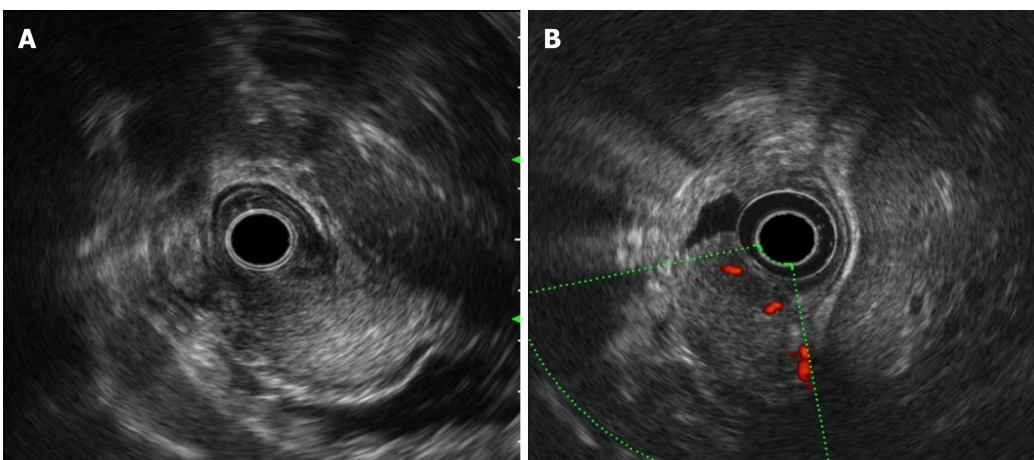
Rich blood flow in the lesion under Doppler ultrasound. A: Endoscopic ultrasonography revealed that the lesion originated from the submucosal layer, which was heterogeneous and hyperechoic, and the posterior muscularis propria and serosal surface were present; B: The blood flow was abundant on Doppler ultrasound.
